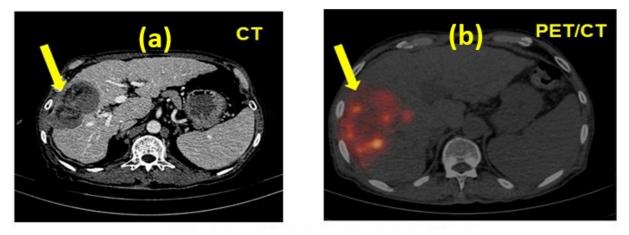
Post-therapy PET/CT image of a 56y male patient with right lobe hepatocellular carcinoma 24 h after administration of 90 mCi [⁹⁰Y]YAS glass microspheres showing biodistribution (a) trans axial CT of liver and (b) trans axial PET/CT of liver. (Image courtesy: Tata Memorial Hospital, Parel)
